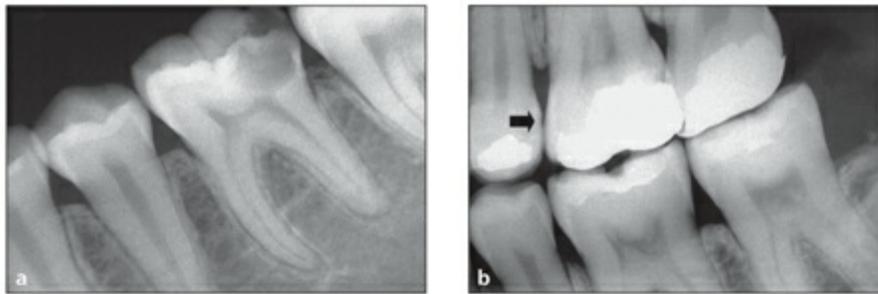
(a) Periapical radiograph showing an advanced dentinal caries lesion. (b) Bitewing radiograph showing approximal caries (arrow).
